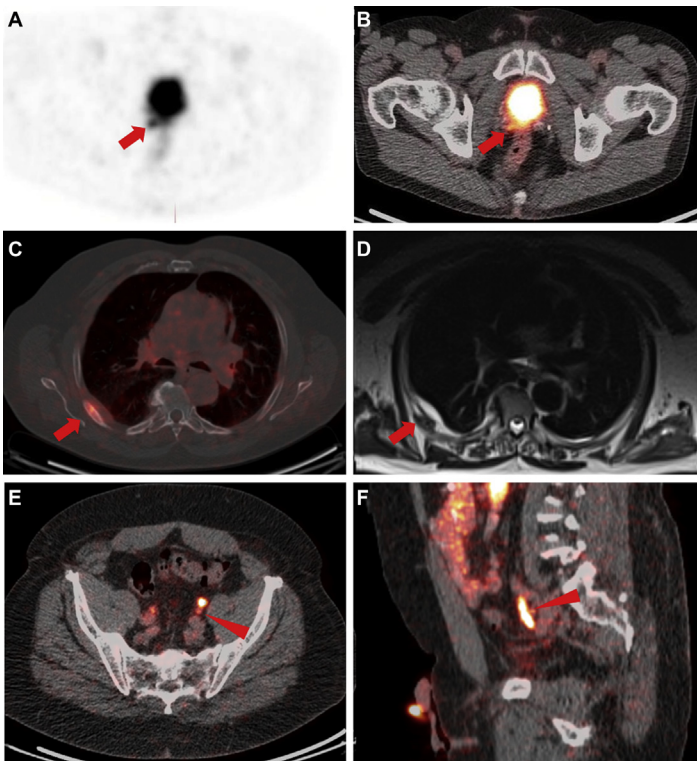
(A) (PET axial) (B) (axial fused PET-CT) 51-year-old man postprostatectomy with positive margin (Gleason 3 + 4 = 7). PSA at time of ^{11}Ga -PSMA PET was 0.23 ng/mL. Uptake in right lateral surgical margin (arrows) obscured by intense bladder activity. Patient underwent EBRT to prostate bed with ADT with subsequent PSA less than 0.01 ng/mL. (C) (PET/CT fused axial) 65-year-old man postprostatectomy presented with PSA of 0.03 ng/mL. ^{11}Ga -PSMA images demonstrate abnormal uptake in the right fifth rib with sclerosis and new soft tissue thickening (arrow). The patient denies trauma. An MR image (D axial T2 HASTE) showed a characteristic healing fracture (arrows). (E) PET/CT fused axial and (F) sagittal images demonstrate abnormal uptake in a left external iliac lymph node measuring 0.6×0.5 cm behind and obscured by intense left ureteral activity (arrowheads).
